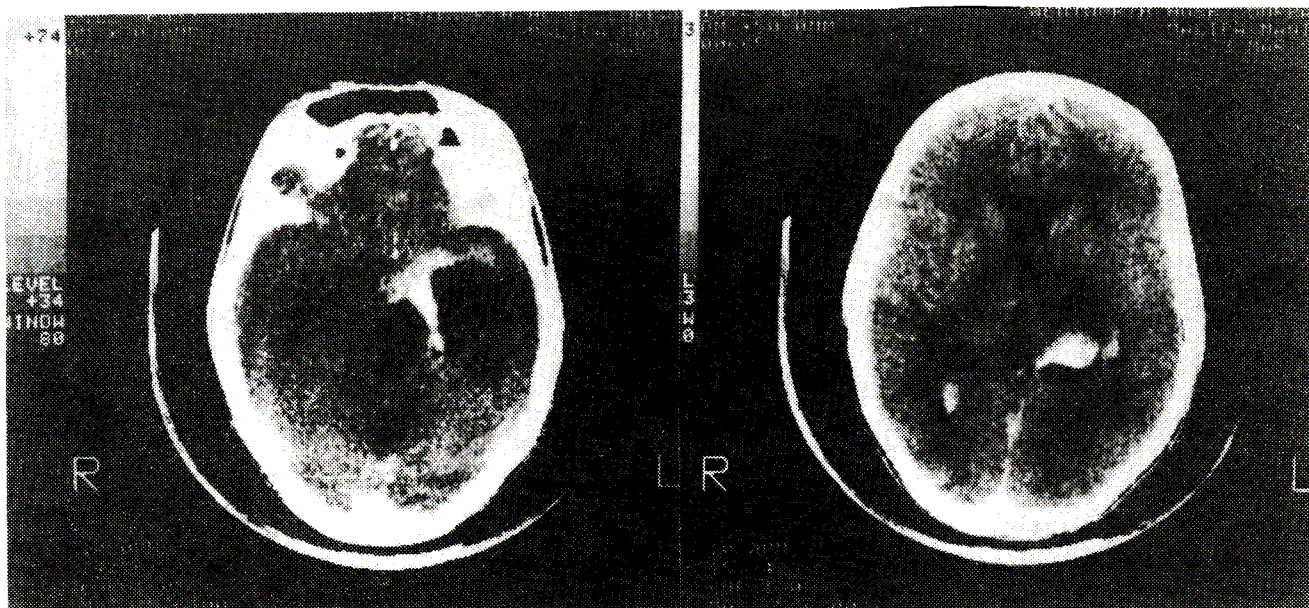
(a,b) CT on admission (CT-Fisher 3).
